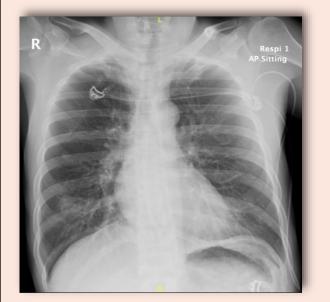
Pre-intubation Chest Radiograph
